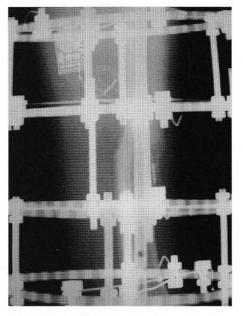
AP radiograph 4 months postoperative.
